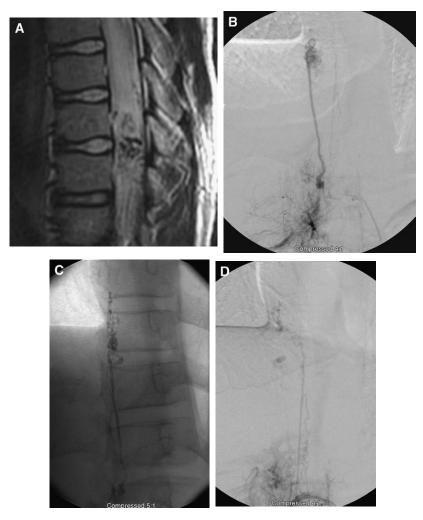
(A) MRI shows a compact intradural arteriovenous malformation (AVM) at T9 to T10 in a 13-year-old boy with a gait disturbance. (B) Selective injection of the right T12 radicular branch shows the compact nidus. (C) Unsubtracted posterior-anterior view shows the glue cast within the arterial feeder and nidus. (D) Postembolization angiogram confirms minimal residual opacification of the AVM. The AVM was completely excised without complication.
